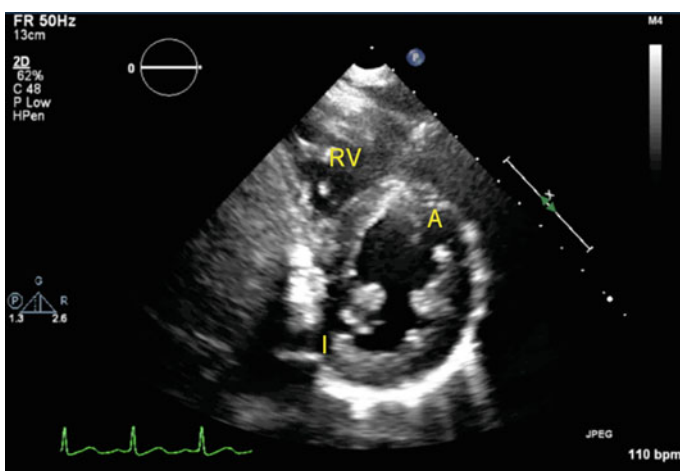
Parasternal SAX mid-papillary view of the LV. *RV* right ventricle; *A* anterior LV wall; *I* inferior LV wall
